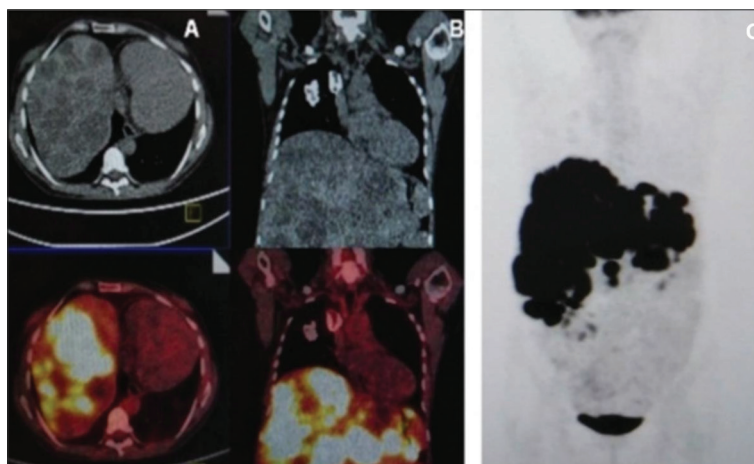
A – axial CT, fused PET/CT; B – coronal CT, fused PET/CT; C – (maximum intensity projection) PET images of elevated right semi-diaphragm with heart dislocation to the left hemithorax
